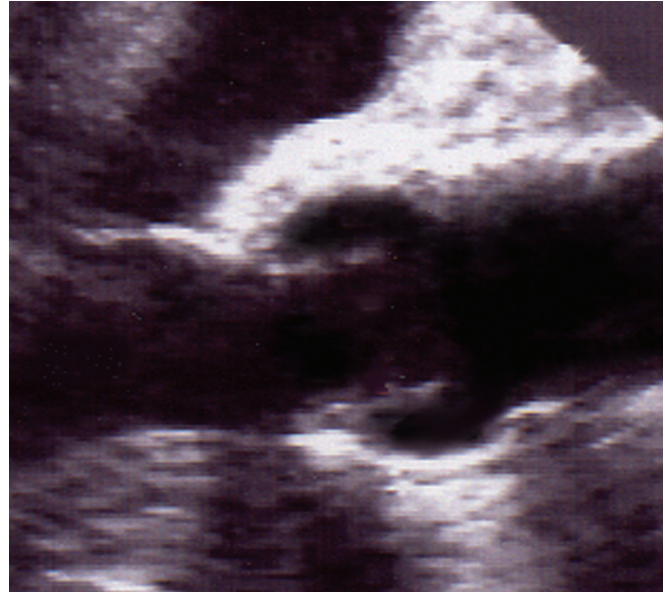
Transesophageal echocardiographic long-axis view of a patient after a reimplantation type of valve-sparing procedure with the Valsalva graft (Vascutek, Renfrewshire, Scotland, UK). The sinuses of Valsalva are well reproduced and they prevent the contact of the valve leaflets against the prosthesis.
